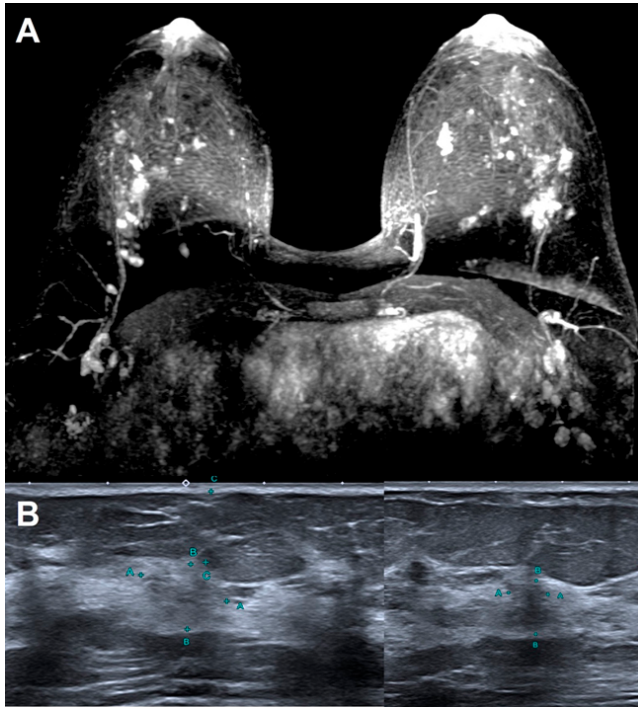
(A) Breast MRI showing suspicious focal nonmass enhancements in both breasts. (B) Second-look ultrasound showing discrete hypoechoic areas in the left breast, which corresponded to PET/CT findings.
